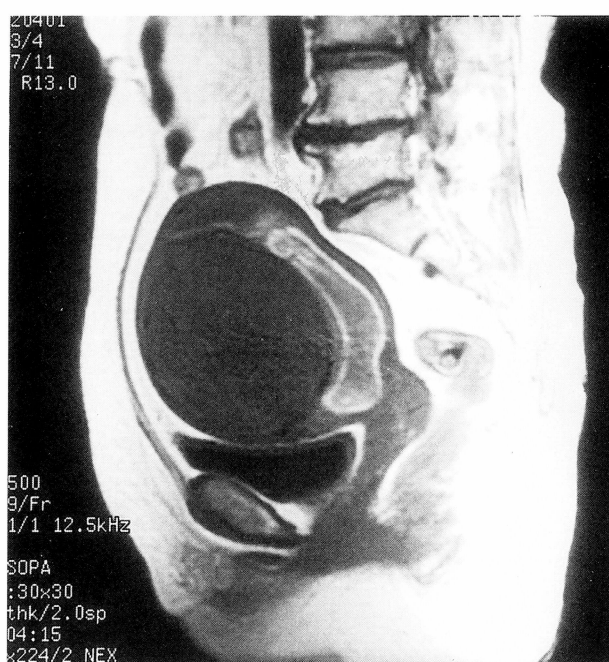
Sagittal T1-weighted MRI showing a submucosal uterine leiomyoma and hematometra.
